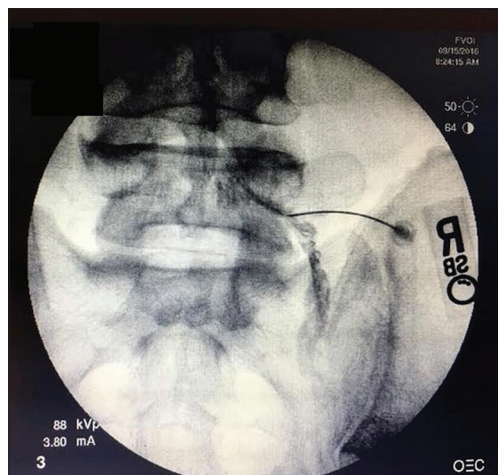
PA x-ray of lumbar spine demonstrating adequate contrast spread at the right L4 nerve root
